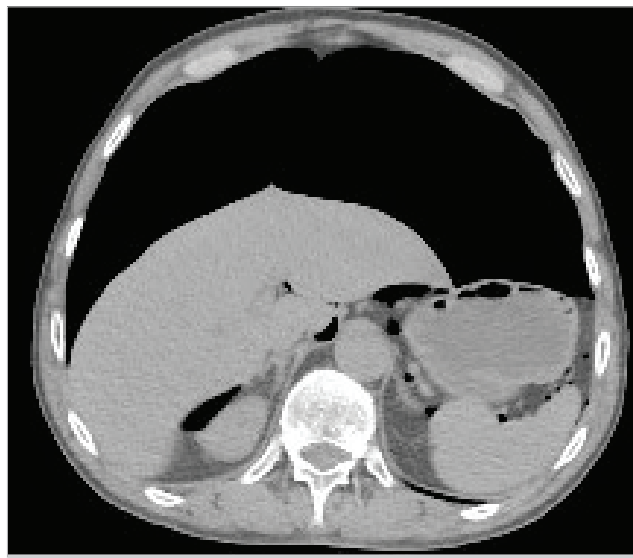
Free air visualized in computed tomography image.
